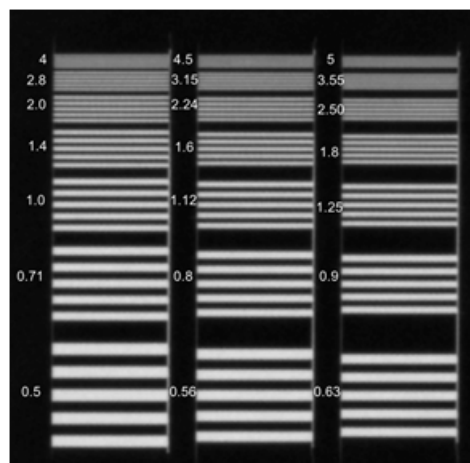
Spatial resolution estimation for the X-rays system. The bar pattern of 3.55lp/mm can be easily distinguished.
